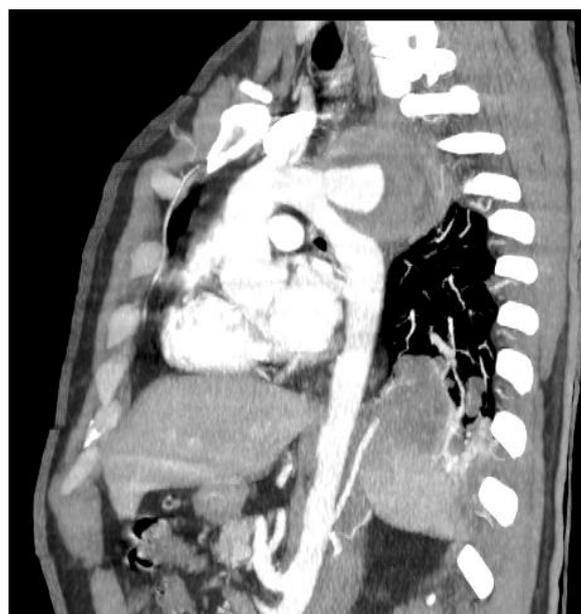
Sagittal CT MIP reconstruction: false aneurysm of the aortic arch
